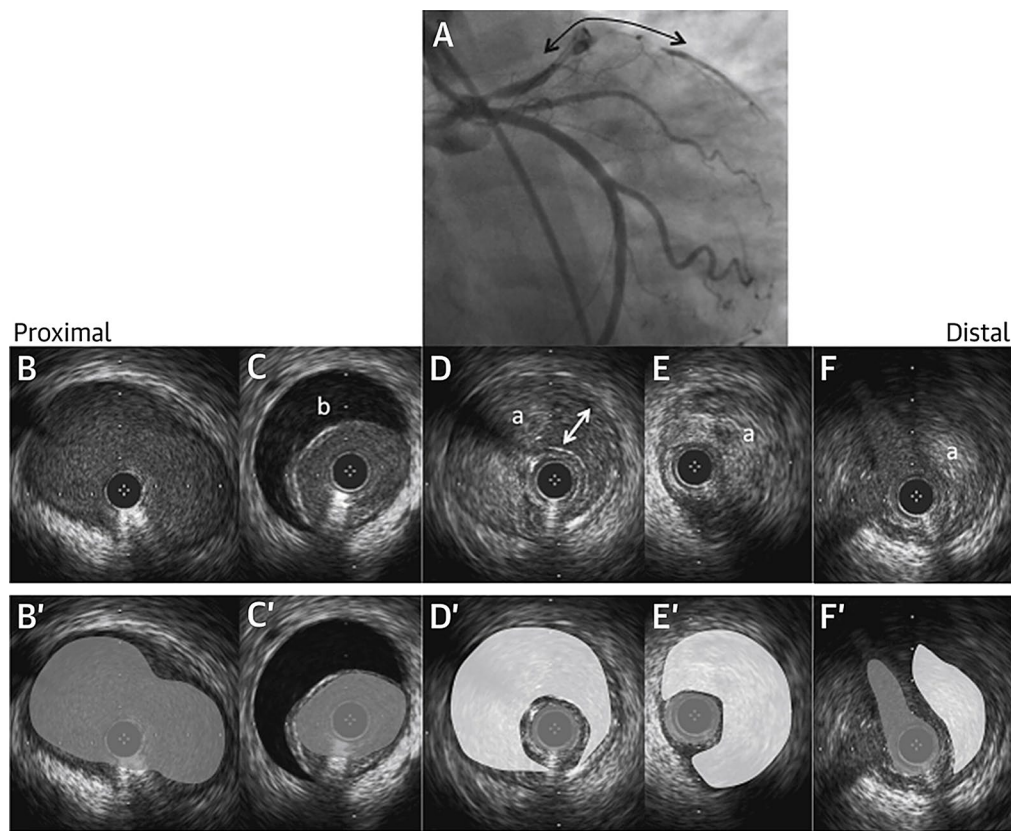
Imaging of IVUS. (A) Coronary angiography showed a severe stenosis from proximal to distal left anterior descending artery (double-headed black arrow). Corresponding intravascular ultrasound imaging (B to F, with duplicated and annotated images B' to F') showed a spontaneous dissection (double-headed white arrow), intramural hematoma (a) and contrast retention (b). The gray areas on the annotated frames
